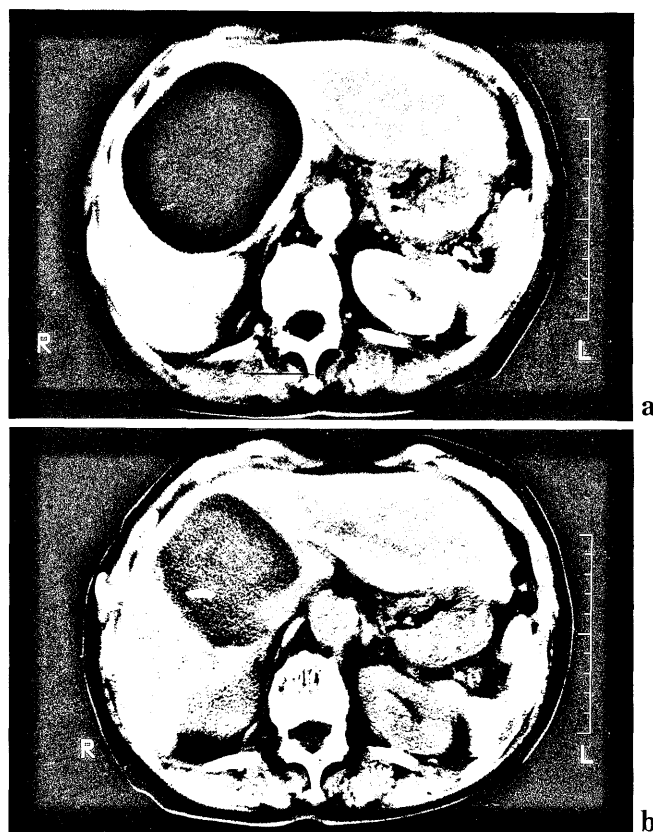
a. CT of the abdomen showing a huge cystic lesion of the caudal lobe of the liver. b. The reduction of the cyst cavity in size can be observed after ethanol injection therapy.
